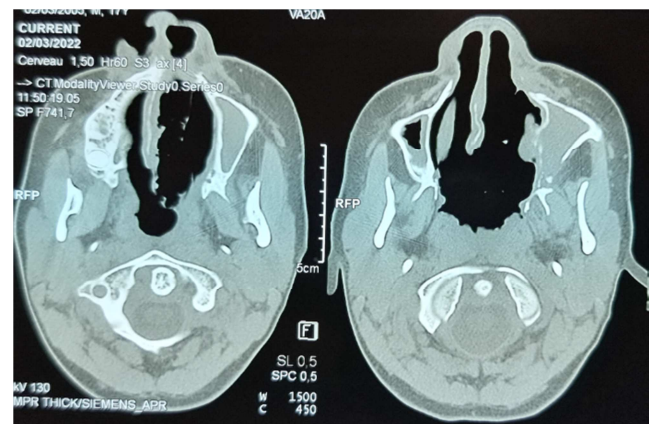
CT Aspects Postoperative at 8 months. Axial section: voids nasosinus cavities and cavum. Presence of bilateral residual maxillary sinusitis.
